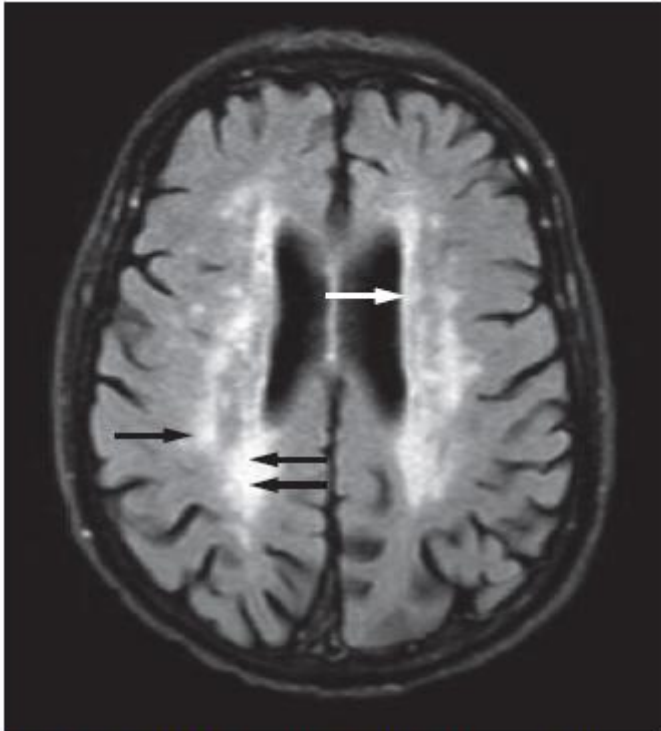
Brain MRI in a patient with parkinsonism. The T2-weighted image shows a section of the brain of a 63-year-old male with lower body parkinsonism. Disruption of the periventricular and deep white matter (white and black arrows, respectively) is seen. Permission obtained from Y. Balash, Tel Aviv Sourasky Medical Centre, Tel Aviv, Israel.
